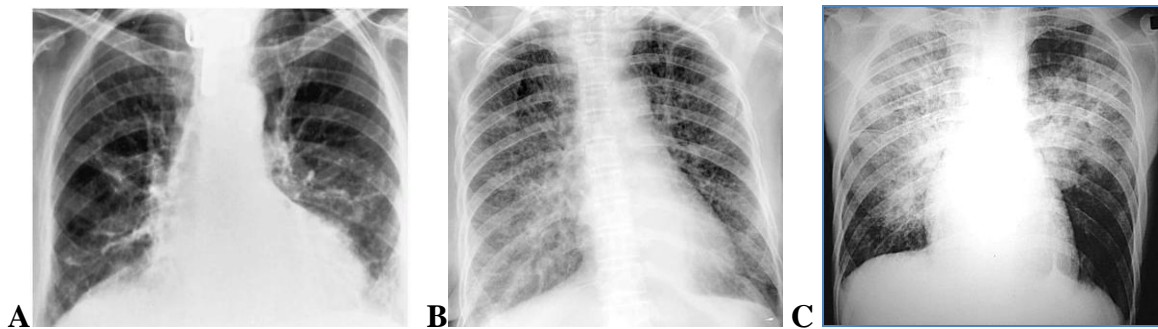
(A to B) Interstitial pneumonia. Notice the excessive number of linear and irregular shadows throughout the film. In subtle cases it may difficult to distinguish the increased linear prominence from normal vessels. (C) Pulmonary edema in congestive heart failure. Diffuse, coarse reticulonodular pattern. Chest radiograph demonstrates a paucity of vascular markings along with increased interstitial markings elsewhere. With the onset of congestive heart failure, there is patchy interstitial and alveolar edema that does not affect the segments in which the vascularity had been severely diminished. Diffuse bilateral symmetric infiltration of the central portion of the lungs along with relative sparing of the periphery produces the butterfly, or bat's wing, pattern
